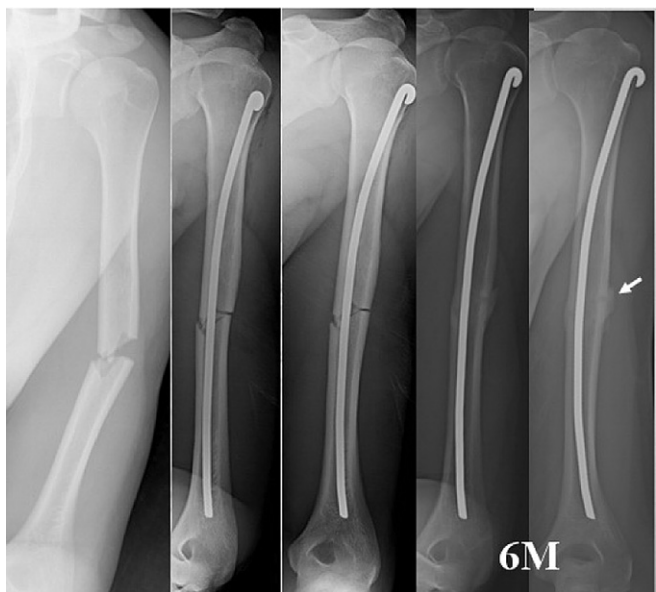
Radiographs of a 32-year-old, 178-cm-tall man who sustained an isolated AO type A3 humeral shaft fracture secondary to a motor vehicle accident. Operation was done by closed reduction and intramedullary fixation using one 28-cm Rush pin; a typical “3-point” fixation was achieved. Obvious union with callus formation was found 6 months after operation, and the patient regained almost normal function of the shoulder.
